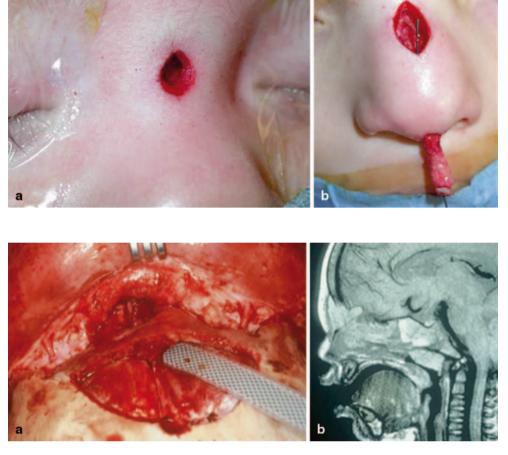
a Intraoperative photograph of an intracranial dermoid cyst being excised via a bicoronal approach with bifrontal craniotomy. b MRI of same patient
